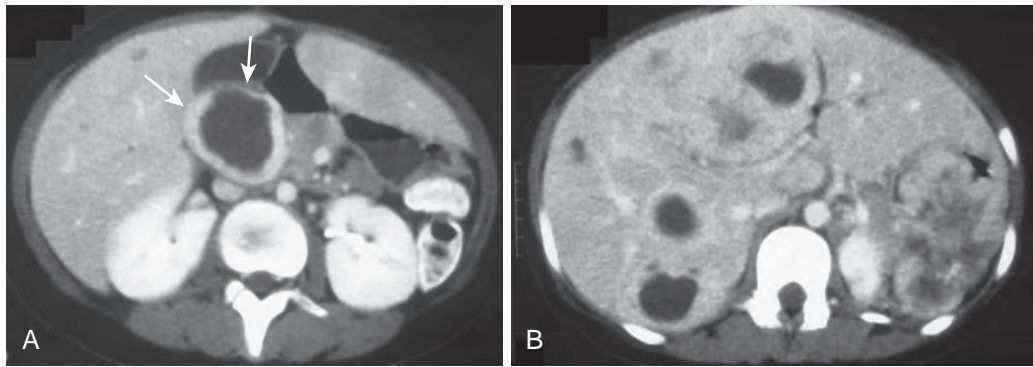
Pancreatoblastoma. A. CT demonstrates a large, well-defined mass in the head of the pancreas (arrows) of a young boy with pancreatoblastoma. B. CT scan through the liver demonstrates multiple, heterogeneous masses within the hepatic parenchyma consistent with metastatic disease.
